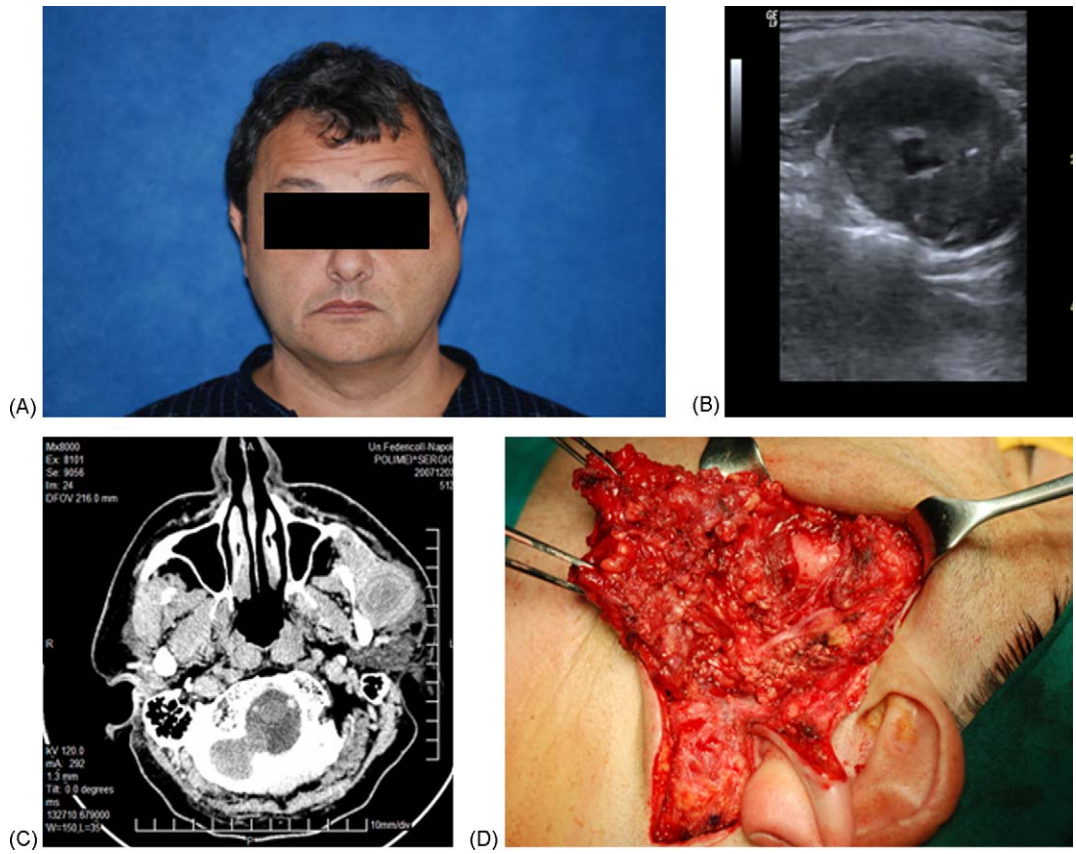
(A) Clinical image showing swelling in the left preauricular region. (B) Ultrasound reveals a 4 cm intramuscular hypoechoic mass with calcifications. (C) CT image demonstrates a tumour mass in the left masseter muscle. (D) Intraoperative image shows a tumour within the masseter muscle.
